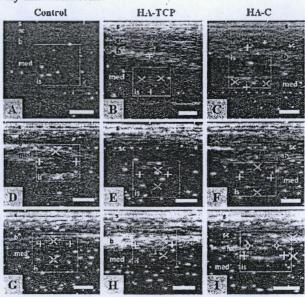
Ultrasound (US) images of control, HA-TCP graft implanted, HA-C graft implanted tibial bone. A: Undrilled bone, D.G: Drilled bone at 21 and 30 days. B,E,H: HA-TCP implanted at 7, 21 and 30 days. C,F,I: HA-C implanted at 7, 14, and 30 days. s, skin; sc, subcutan; b, bone; med, medulla; is, implant site; arrow (→), anechoic image indicate that site consist of liquid, site of implant (□), size of hole site was showed by the distance between two "+" and two "x" mark. Bar = 10 mm.
